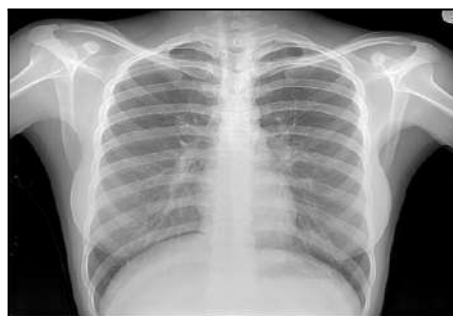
example of chest x-ray [7] .
